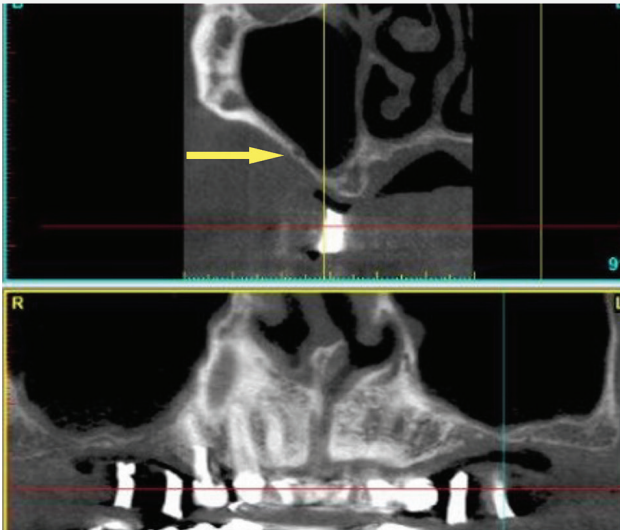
CT scan showing intraosseous AAA (yellow arrow) in area of planned window preparation. This case is shown in video.
